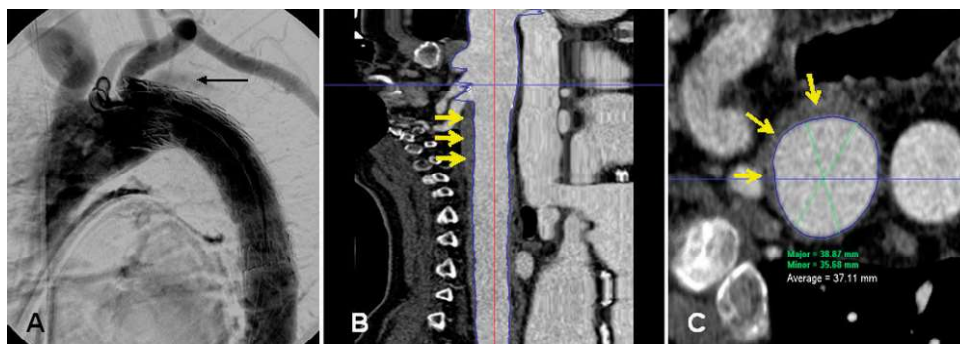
♦ (A) Completion angiography after stent-graft deployment shows contrast enhancement at the outer curve (arrow). (B) Centerline postprocessing demonstrates wall thickening and intramural hematoma reaching the left subclavian artery (arrows). (C) This orthogonal view of a CTA reconstruction indicates aortic arch involvement representing retrograde dissection.
